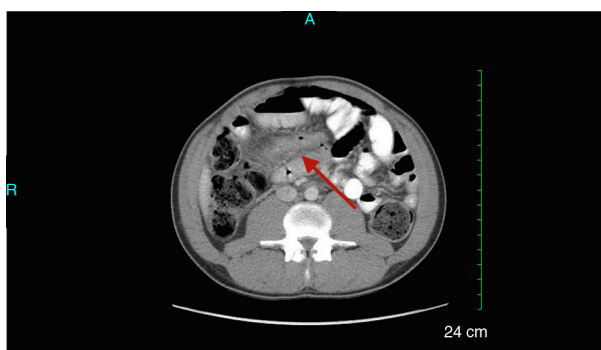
CT abdomen pelvis with contrast. Findings consistent with an abdominal viscus perforation with extravasated bowel contents in the right lower quadrant.
